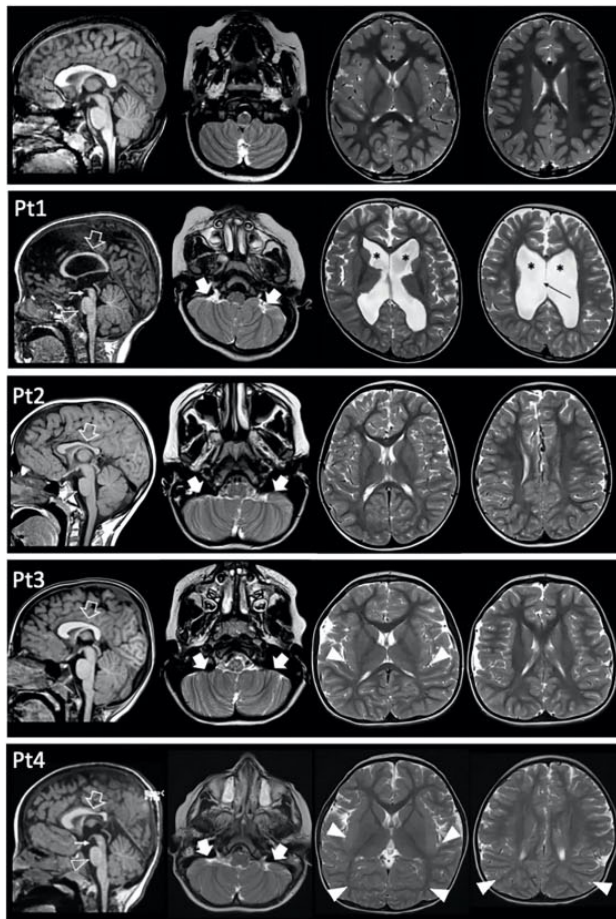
Clinical and neuroimaging features of individuals with *RAC3*-related disorder. (C) Brain MRI, sagittal T1-weighted and axial T2-weighted images, of Patients #1-4 and of a normal individual (first row) for comparison. The corpus callosum is shorter and thinner in all patients, especially at the level of the splenium (empty arrows), with thick genu in Patients #3 and #4. Note the absence of the anterior commissure in all patients. The volume of the cerebral white matter is reduced in all patients, with marked ventricular enlargement (asterisks) and septal defect (black thin arrow) in Patient #1. Diffuse dysgyria is present in all subjects, associated with polymicrogyria in the posterior regions in Patients #3 and #4 (arrowheads). Bilateral cerebellar folia abnormalities are noted in the inferior portions of the cerebellum in all patients, especially on the left side (thick arrows). There is hypoplasia of the midbrain in Patients #1 and #4 (white thin arrows) and a small pons in Patients #1, #2, and #4 (empty arrowheads). Mild enlargement of the subarachnoid spaces is noted in all patients, while brachycephaly is present only in Patients #3 and #4.
